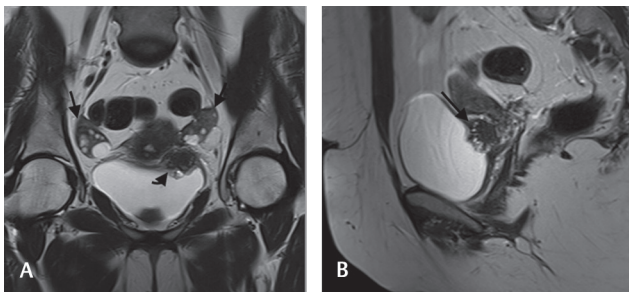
(A, B) Cor (A) and sag (B) T2W images showing a deep extrinsic deposit on the bladder (arrow in B) with intact mucosa (arrowhead in A). Note that the ovaries are bilaterally normal (arrows in A). T2W, T2-weighted.
